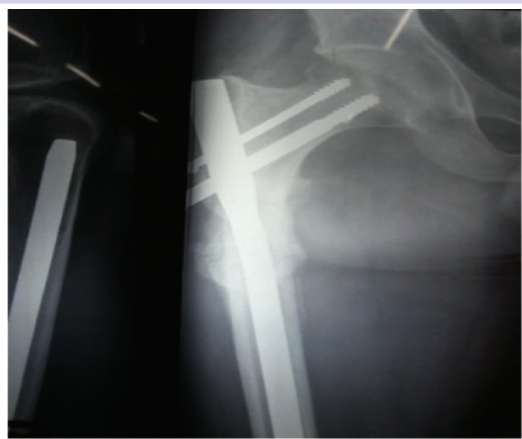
Showing after 6 months post-operative x-ray
